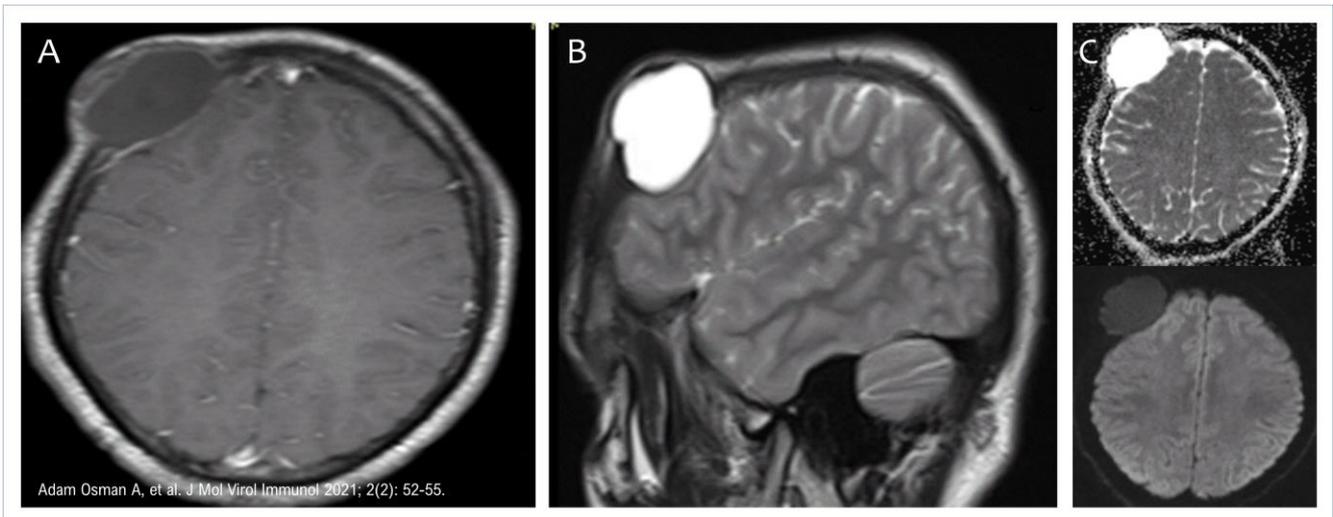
Axial post-contrast T1-weighted image (A) shows that the cyst is hypointense and has no contrast enhancement. Sagittal T2-weighted image (B) reveals a large calvarial defect and a cystic lesion. Diffusion-weighted image (C) shows that the cyst has no restricted diffusion.
